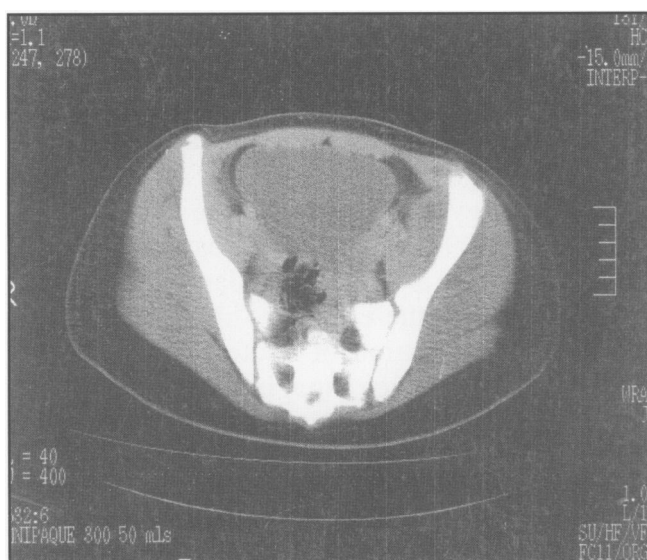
CT scan of the pelvis showing periosteal reaction left ilium and abscesses in the iliacus and gluteus minimus muscles.
